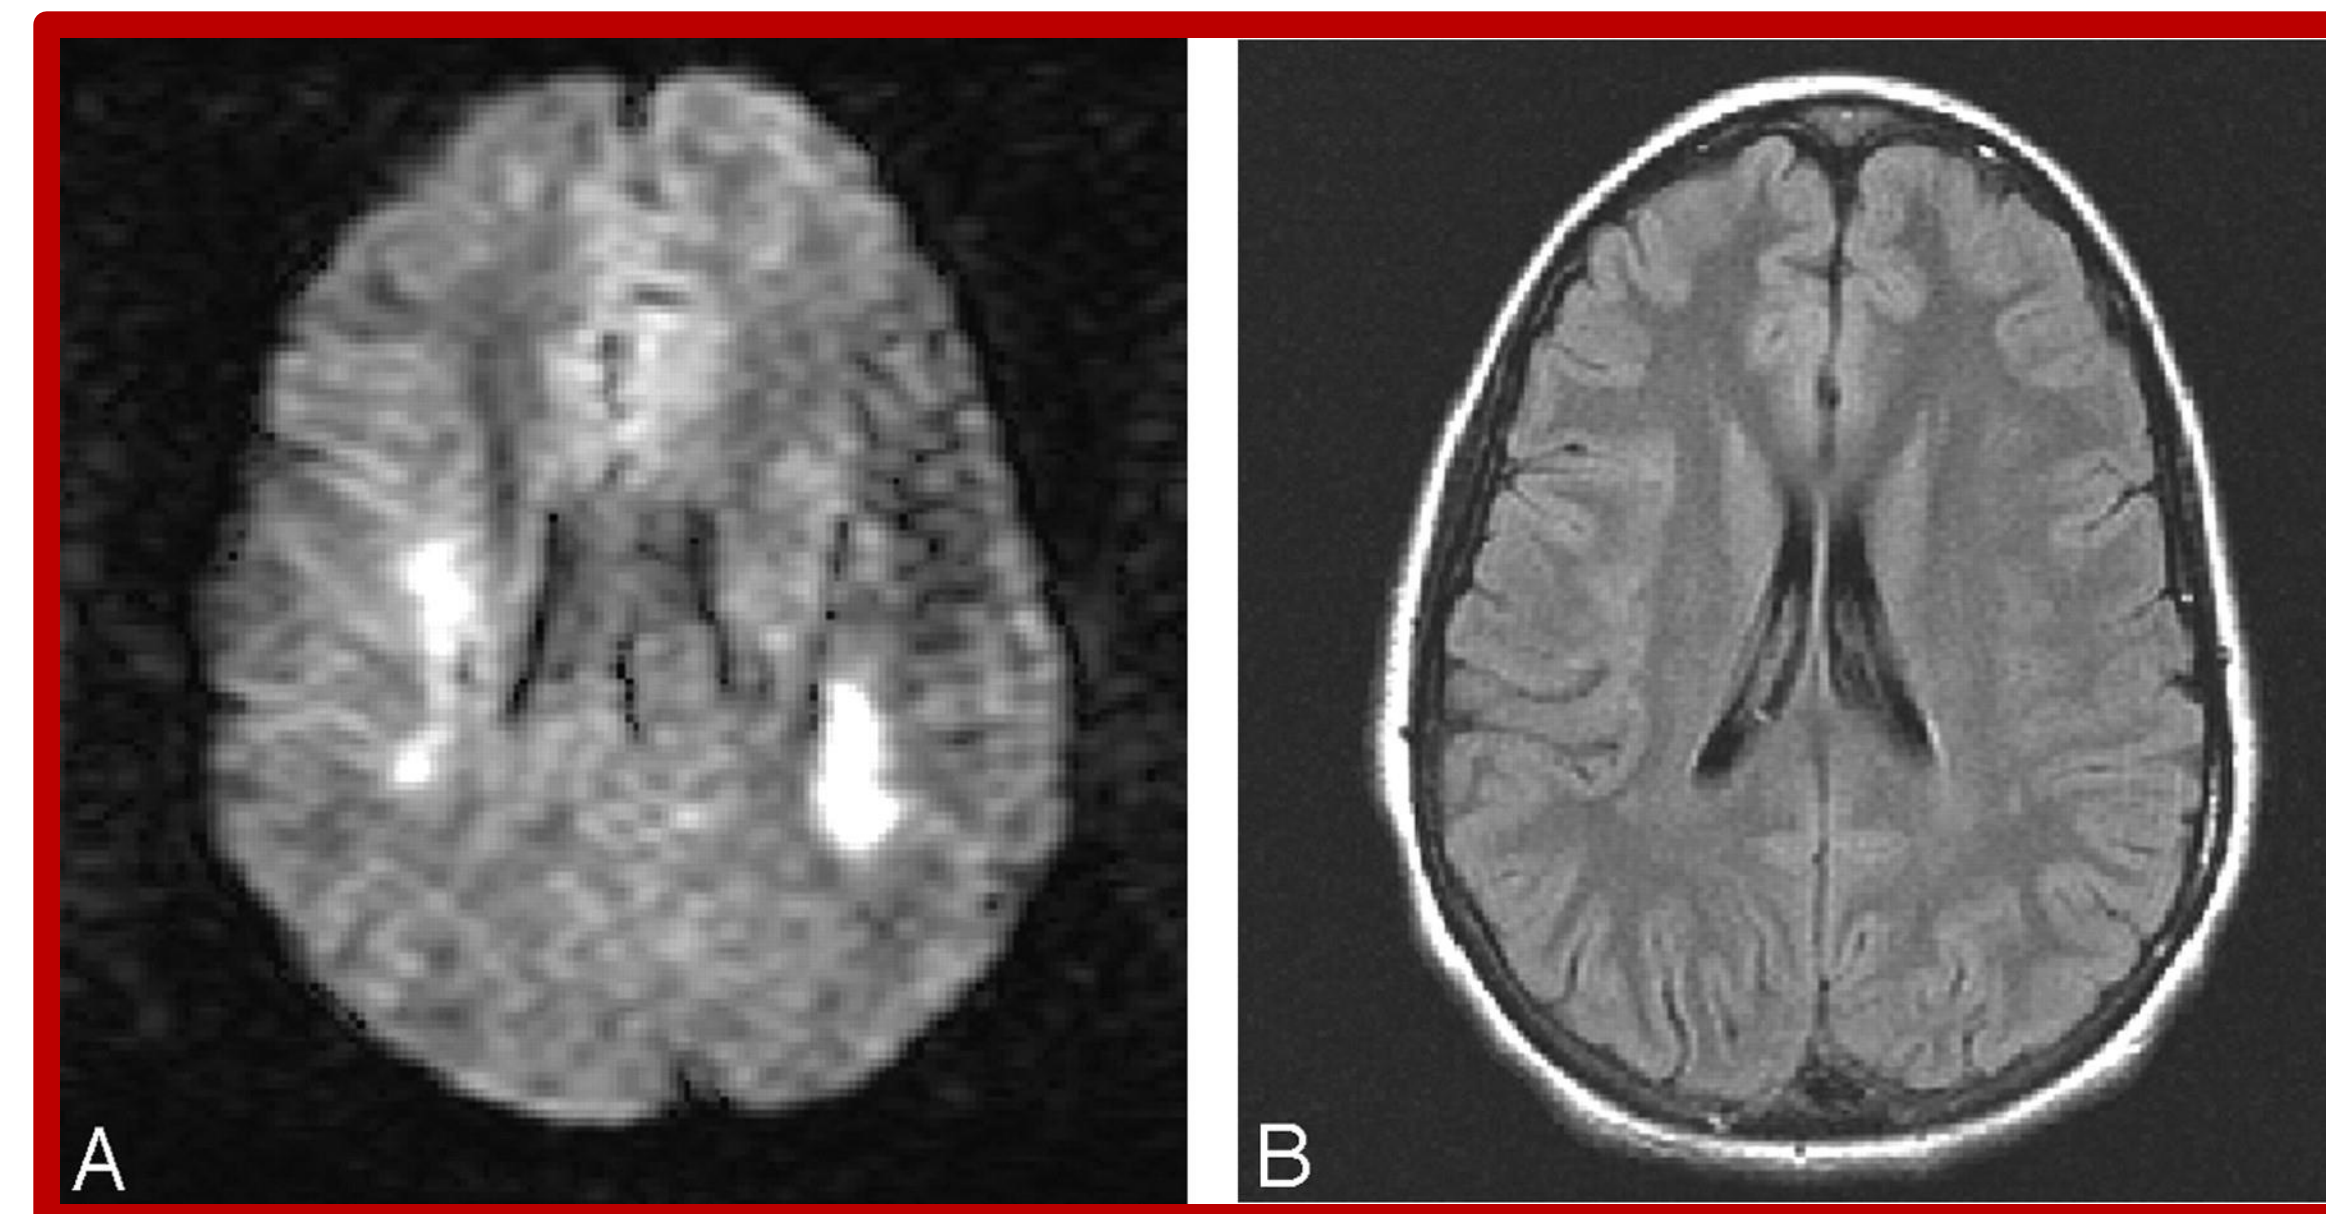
A pediatric patient presenting with nonfluent aphasia and bilateral UE weakness following intrathecal MTX administration. Image A is an axial DW image evidencing restricted diffusion in the centrum semiovale accounting for the arm weakness. Image B is an axial FLAIR at 39 months s/p neurotoxicity showing minimal abnormal T2 signal intensity consistent with demyelination. Neurological deficits had resolved.
